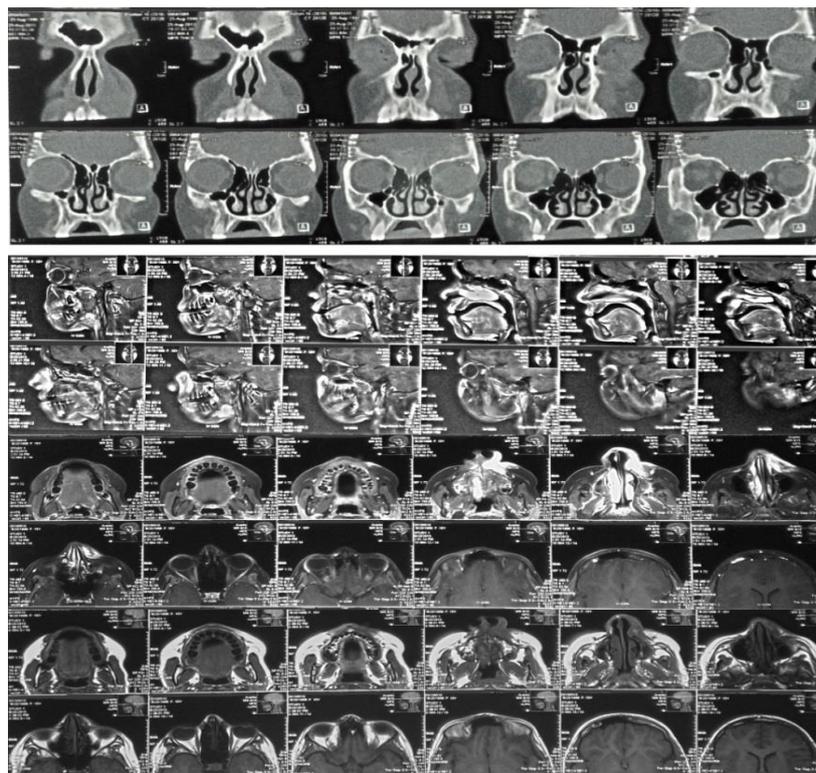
Computed tomography scan (CT scan) and magnetic resonance imaging (MRI) of maxillofacial region
